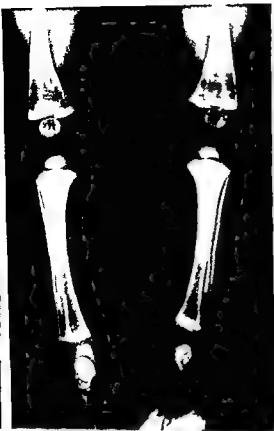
Radiograph of lower limbs of M J K at age 18 months showing coarse trabecular pattern and splayed epiphysis
